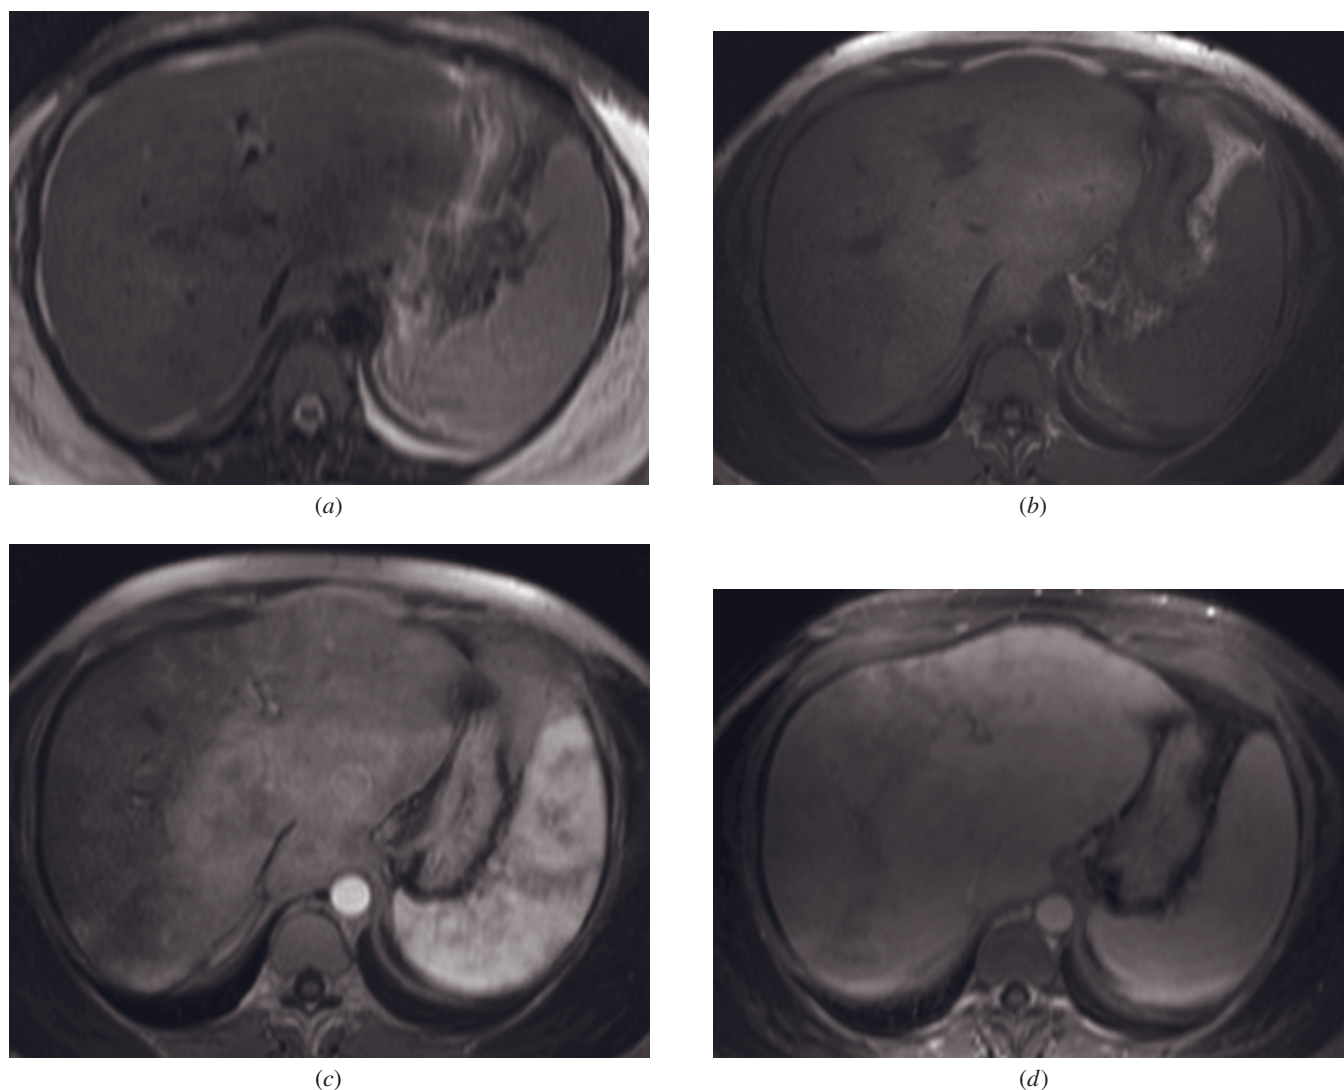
Acute Budd–Chiari syndrome. T2-weighted ETSE (*a*), SGE (*b*), immediate (*c*), and 90-s postgadolinium SGE (*d*) images. The T2-weighted image (*a*) shows normal signal intensity of the caudate lobe and central liver and mild heterogeneous higher signal intensity of the peripheral liver. On the precontrast T1-weighted image (*b*), the caudate lobe and central portion of the liver are normal in signal intensity, whereas the peripheral liver is low in signal intensity. On the immediate postgadolinium image (*c*), the caudate lobe and central liver enhance heterogeneously and intensely, whereas peripheral liver shows lower enhancement. On late phase (*d*) liver appears more homogeneous than early phase but still shows increased enhancement in central areas.
